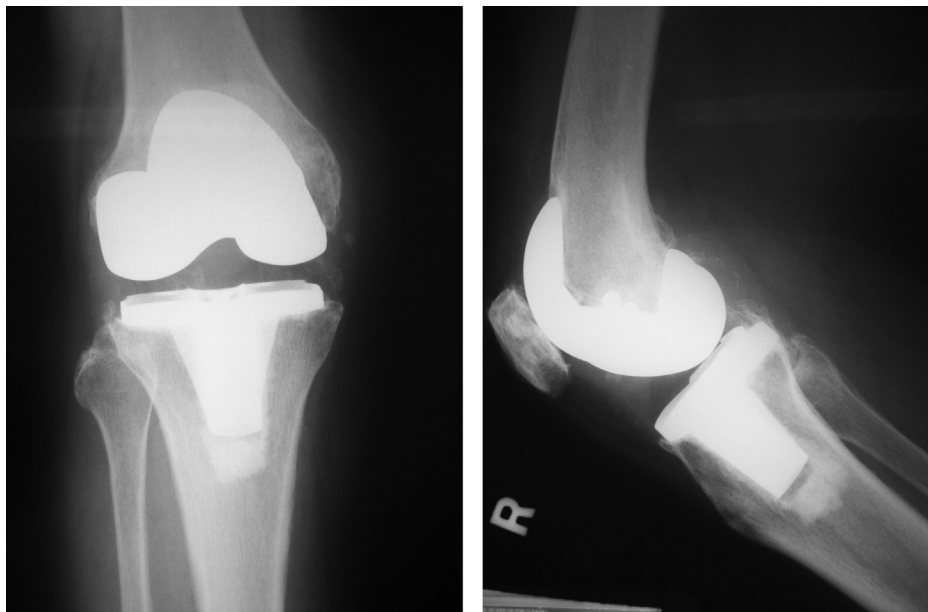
Postoperative radiographs of Case 1.
